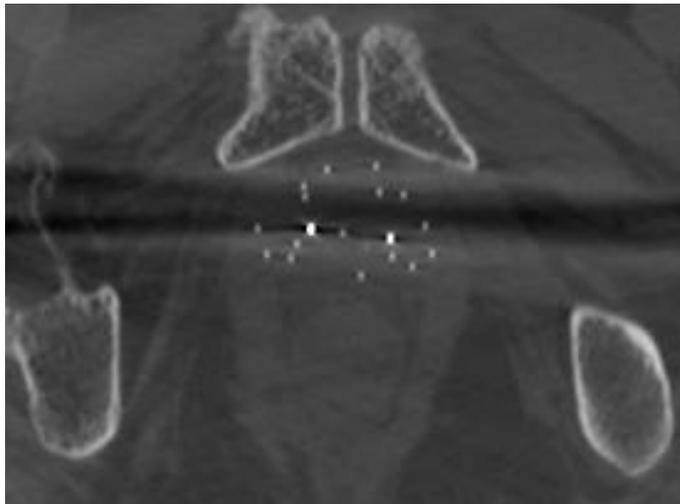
Transverse CT slice from Patient #3 demonstrating clear visualisation of prostate tissue and nitinol marker wires in plastic needles. Two gold fiducial markers are easily distinguished from the needles. Note minimal streak and signal deficit.
